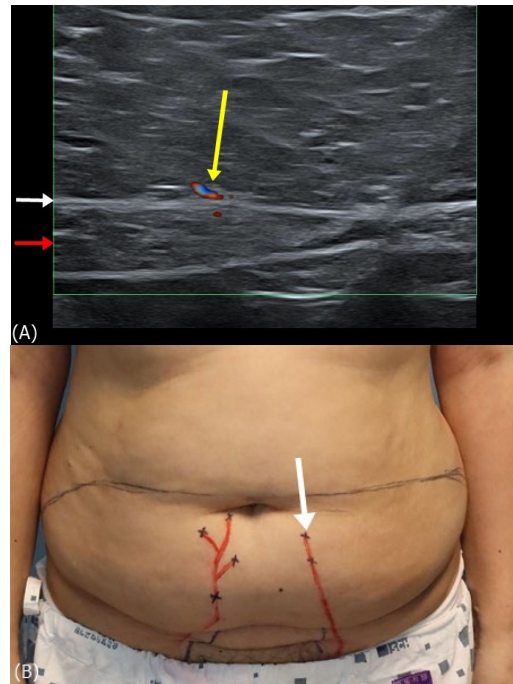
(A) Preoperative ultrasound identified the presumed vascular pedicle within the flap. Arrow; *Yellow*. Deep inferior epigastric artery perforator, *Red*. Rectus abdominis muscle, *White*. Rectus sheath (B) The corresponding surface point was marked preoperatively (white arrow) to guide surgical planning for secondary debulking.
